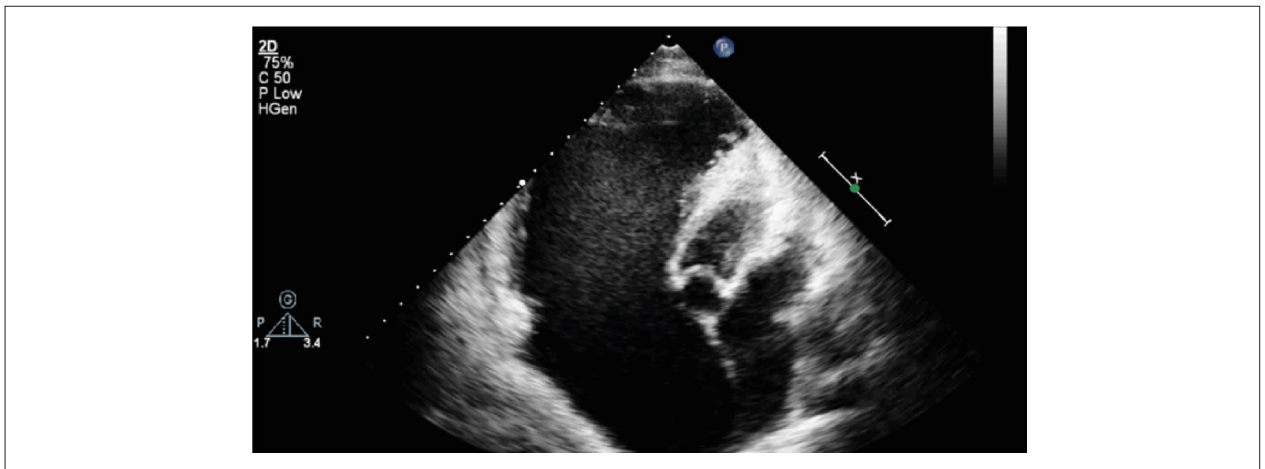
Transthoracic echocardiogram of the parasternal short-axis window showing tricuspid leaflet remnants, normal valve implantation, and right chamber dilation.
